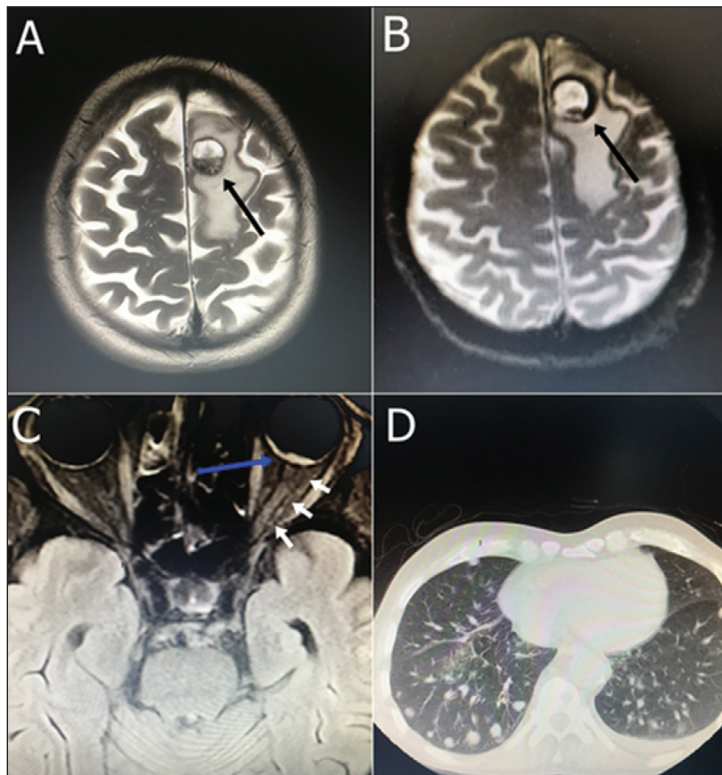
Cranial magnetic resonance imaging (MRI), shows the mass lesion and surrounding diffuse edematous signal changes consistent with hemorrhagic metastasis at the level of the left frontal vertex (indicated with black arrow) (A). Cranial MRI was performed 15 days after external beam radiation treatment. Hemorrhage within the metastatic lesion in the brain is resorbed, while tumor size and surrounding edema remain unchanged (indicated with black arrow) (B). Orbital MRI shows contrast enhancement in the optic disc and surrounding choroid (indicated with blue arrow) consistent with metastasis. No contrast enhancement was observed in the optic nerve behind the optic disc (indicated with white arrows) (C). Axial computed tomography shows multiple round nodules and masses of varying sizes consistent with diffuse metastasis in both lungs (D).
